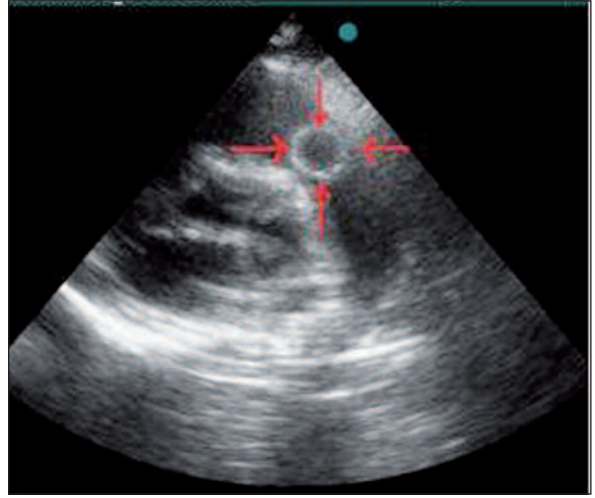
Preoperative echocardiographic view of the cardiac cyst.
